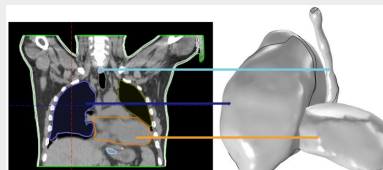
Coronal CT with contoured OARs — heart, esophagus, lung (left) — and corresponding 3D COMSOL solid geometries (right).
